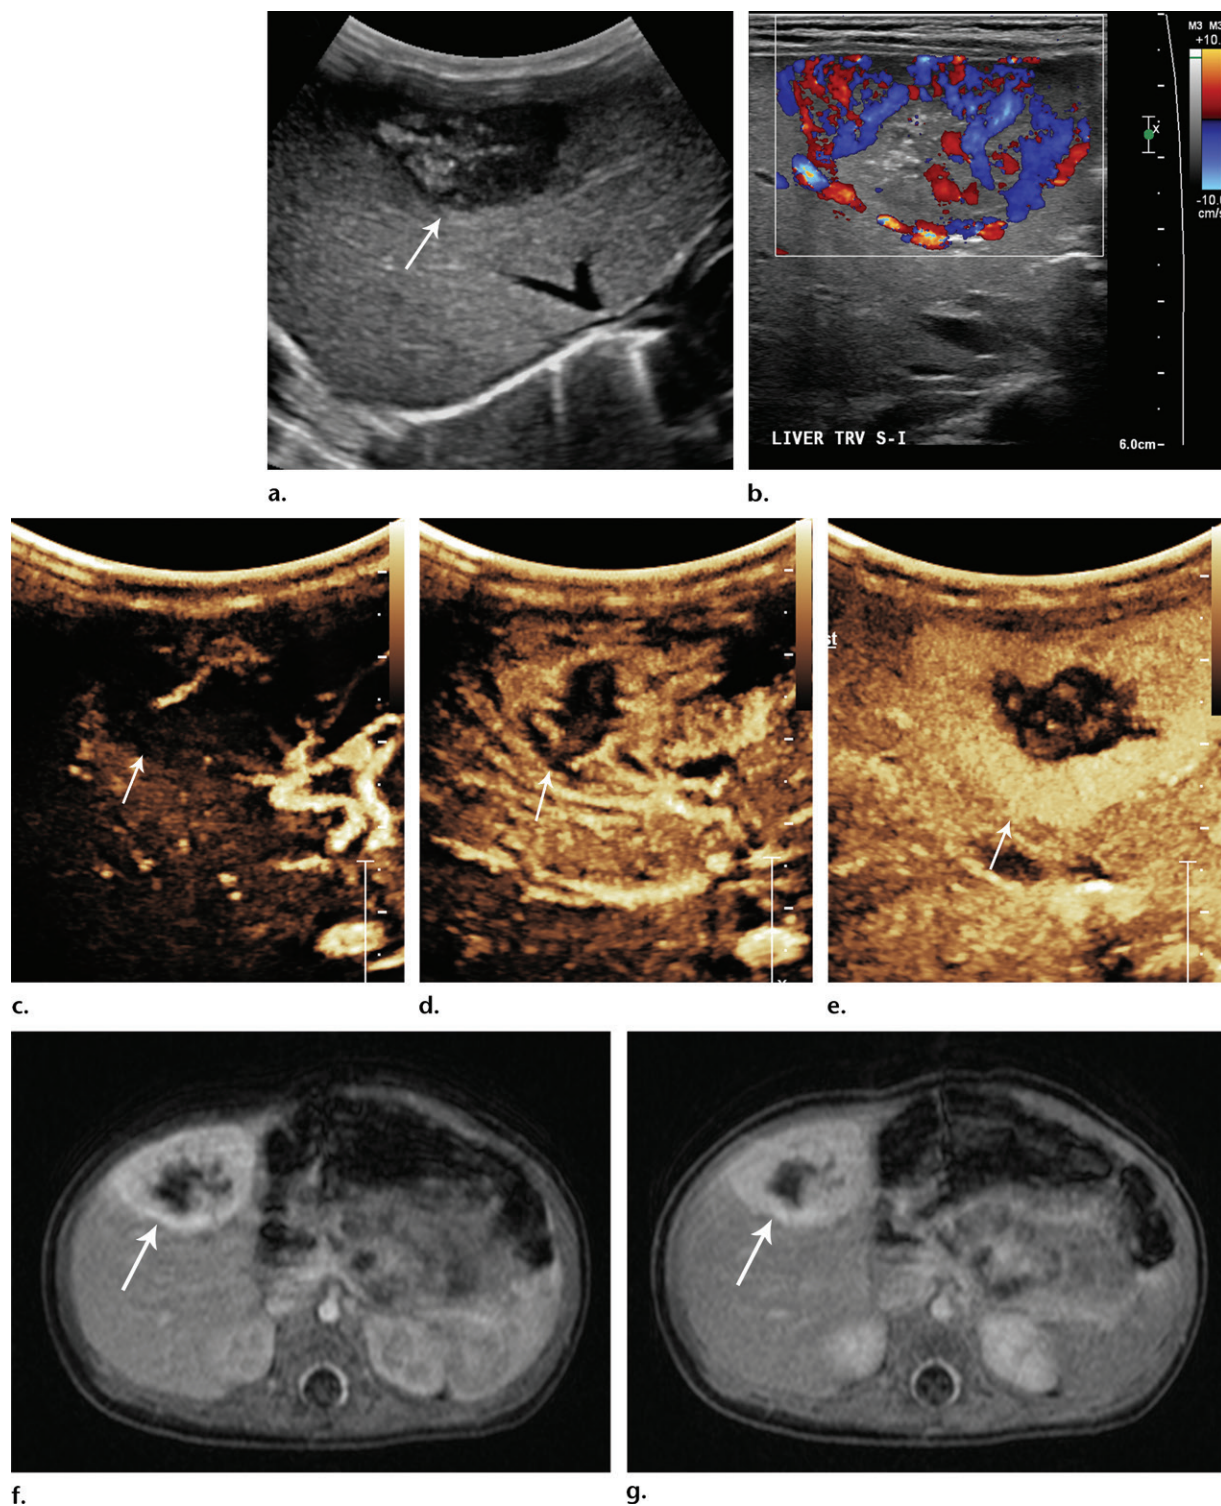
Rapidly involuting congenital hemangioma in a 39-day-old boy in the intensive care unit. This lesion was an incidental finding at pyloric US performed to determine the cause of vomiting. (a, b) Transverse gray-scale (a) and color Doppler (b) US images show a partially calcified focal mass (arrow in a) in the right liver lobe, with increased, predominantly peripheral vascular flow on the color Doppler image. (c–e) Transverse CEUS images obtained during the arterial (c), portal venous (d), and late venous (e) phases of enhancement show progressive centripetal enhancement of the lesion (arrow). (f, g) Similar to the CEUS images, the follow-up axial contrast-enhanced arterial (f) and portal venous (g) phase MR images show a peripherally enhancing lesion (arrow). CEUS revealed the classic enhancement pattern of infantile hepatic hemangioma and was comparable to conventional dynamic contrast-enhanced MR imaging in the evaluation of this lesion, without the need for sedation. MR imaging was performed to further assess this lesion, as intravenous CEUS was in the incipient stage of use. Performing CEUS at this critically ill patient's bedside in the intensive care unit obviated transport to the radiology department.
